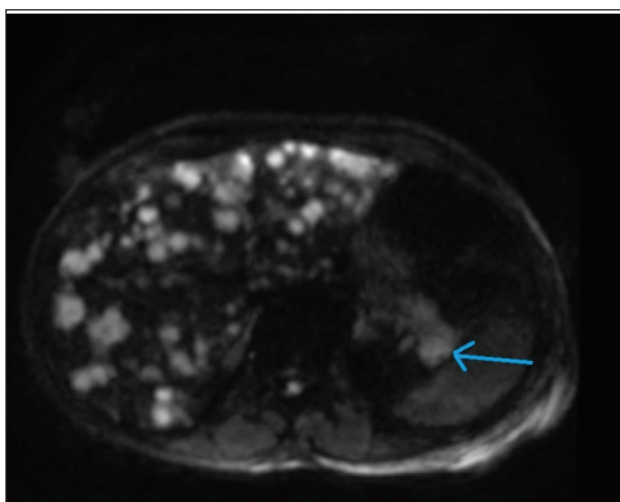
MRI of the liver: Primary malignancy is in the tail of pancreas, 35 × 20 mm with hypovascular liver metastasis. The scan was limited due to motion artefacts. 220 × 172 mm (96 × 96 DPI).
